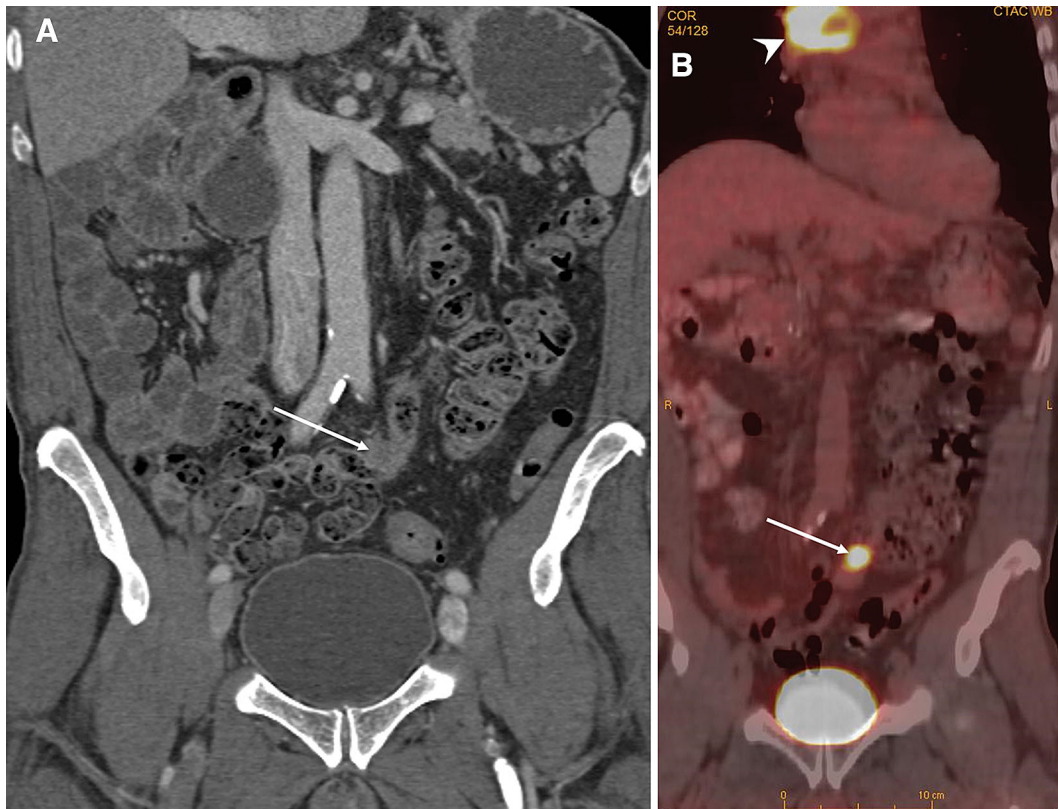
Adenocarcinoma of the ileum in a 56-year-old male who presented with SVC syndrome secondary to mediastinal metastasis. Coronal image from CTE (A) shows focal moderately enhancing mass in the ileum (*arrow*). Coronal fusion image from PET/CT (B) shows intense uptake in the ileum corresponding to the small bowel mass
